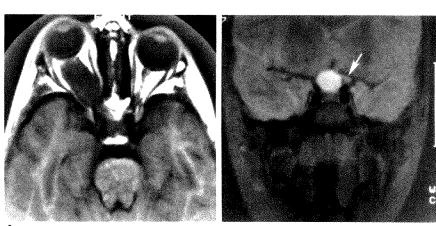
T1-weighted axial, 600/17 (A), and T2-weighted coronal, 2000/90 (B), MR images show right optic nerve pilocytic astrocytoma with posterior extension into optic chiasm. Tumor is hypointense on T1- and hyperintense on T2-weighted images. Left side of optic chiasm is displaced but uninvolved (arrow).
